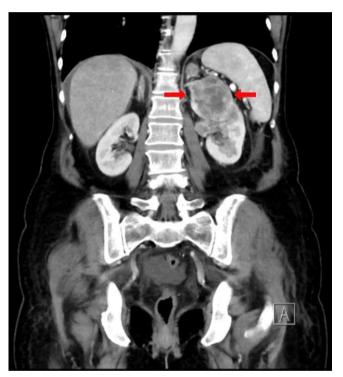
Left kidney with kidney tumor (CT scan)
